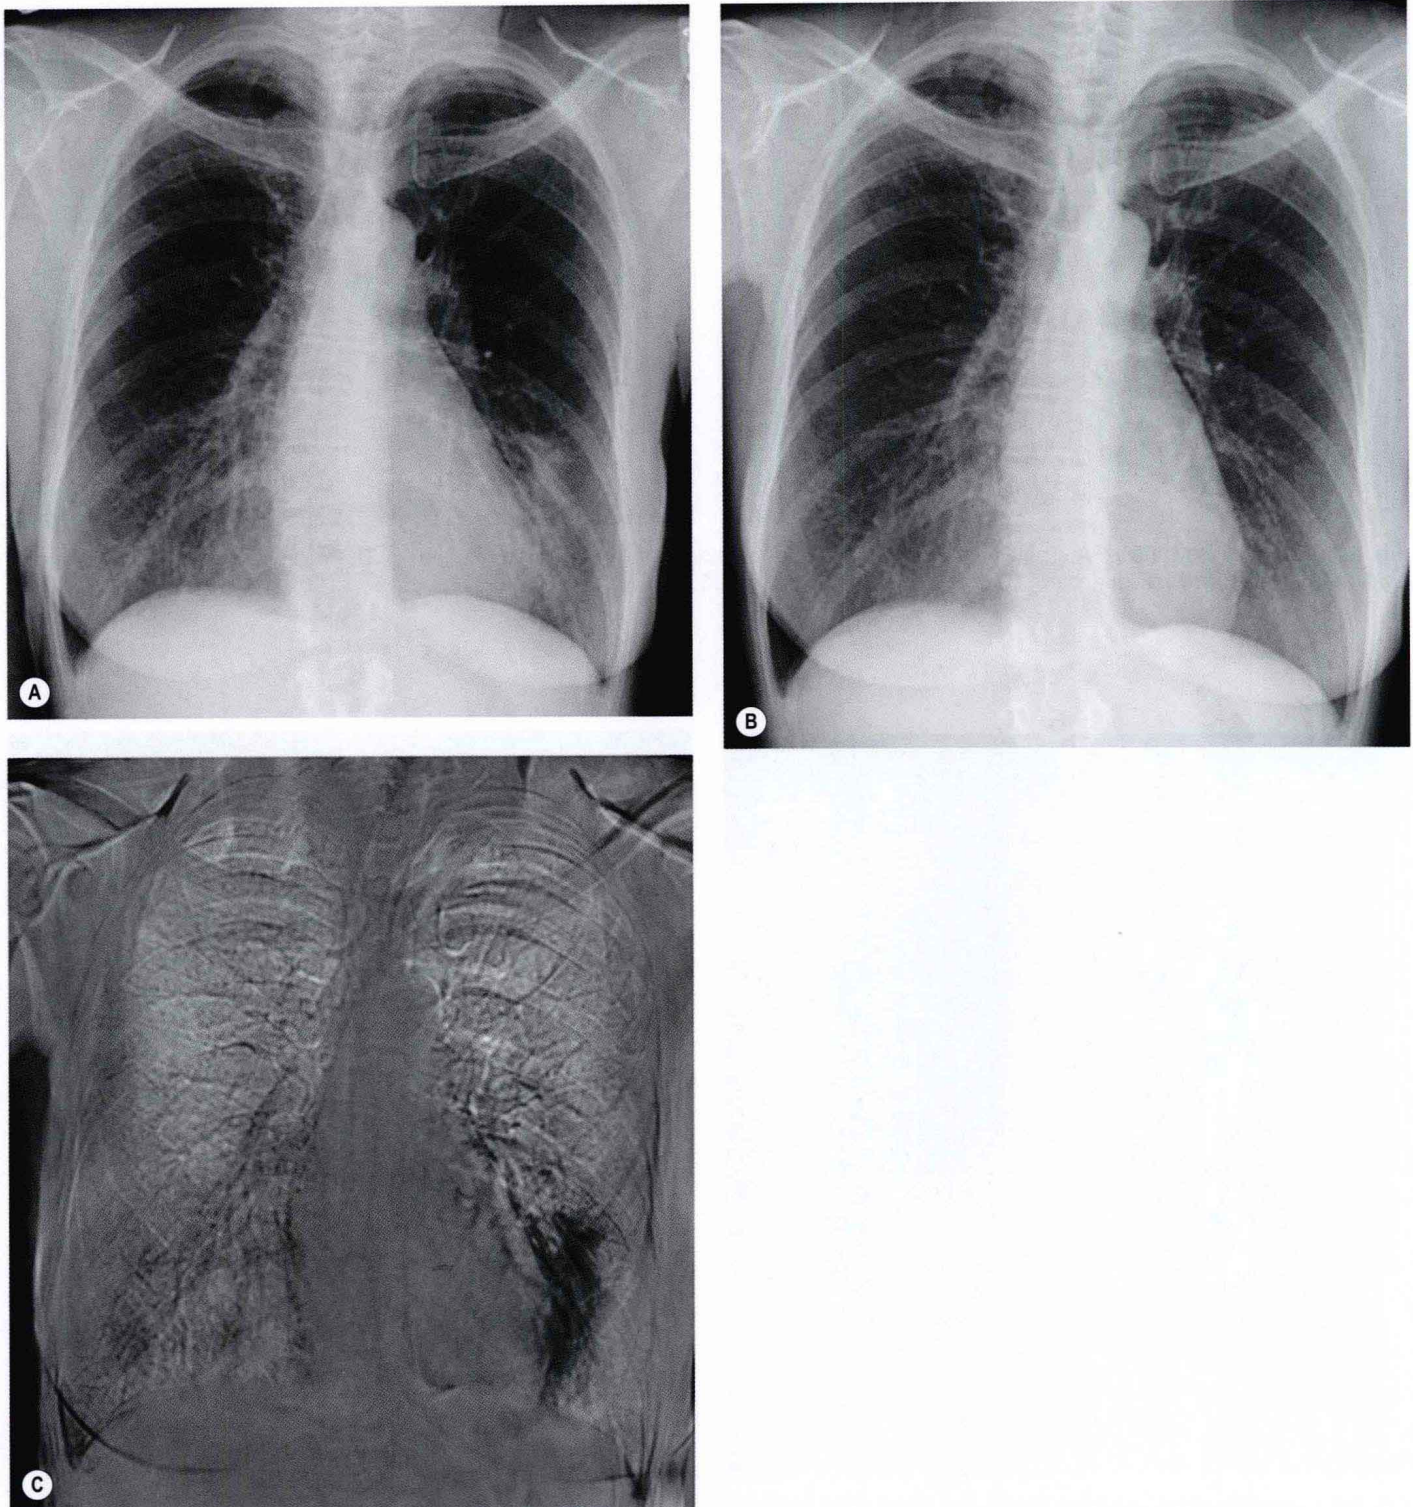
Temporal subtraction. A, Current radiograph shows subtle lingular opacity. B, The opacity was not present on the previous radiograph. C, Temporal subtraction image emphasizes the new opacity. (Courtesy of Heber MacMahon, Chicago, IL, USA.)
